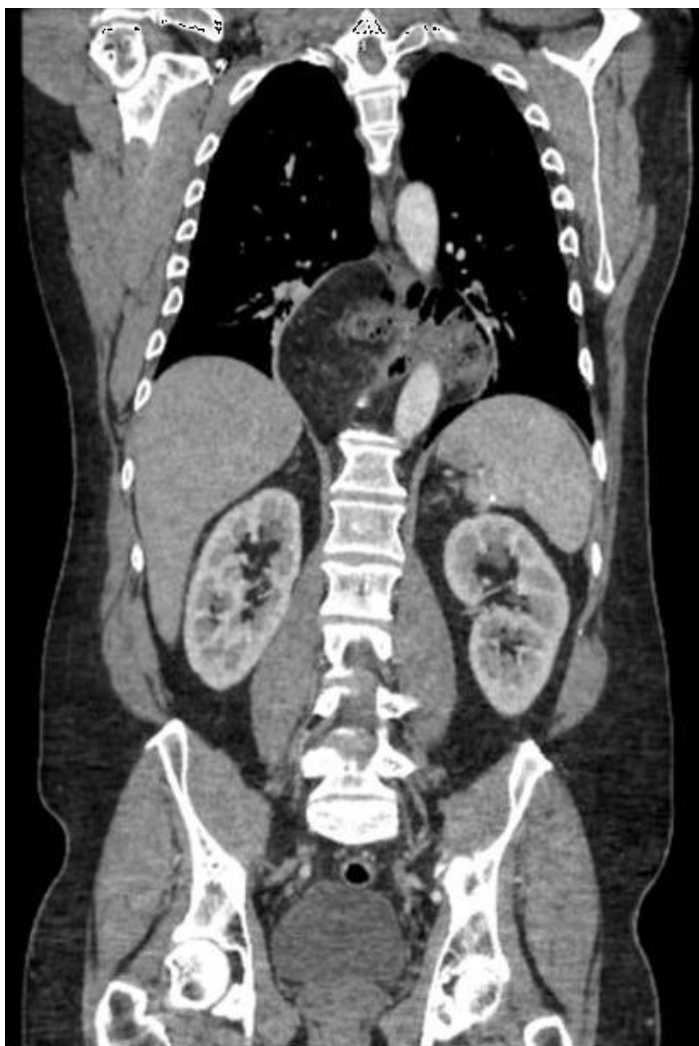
Coronal view of CT chest/abdomen/pelvis showing the hiatal hernia.
